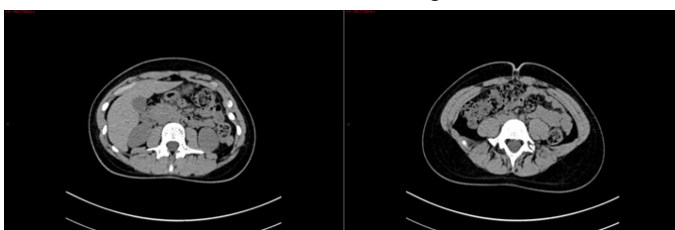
Axial abdominal CT scan.
